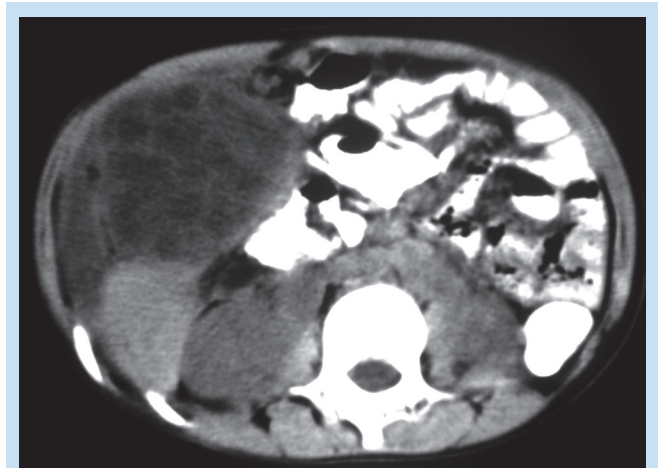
a. Axial contrasted CT scan demonstrates the hepatic hydatid cyst with internal daughter cysts/brood capsules.
